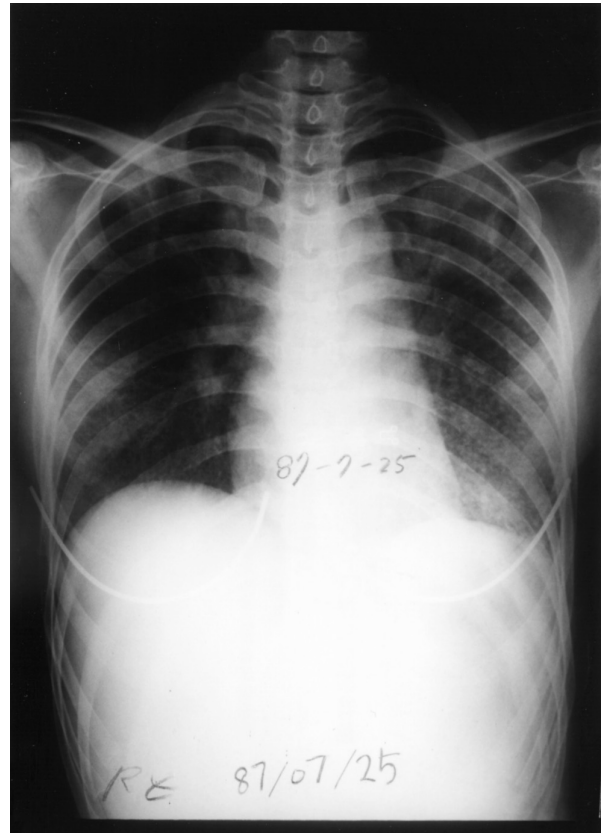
Chest radiograph shows that there were multiple small nodules in both lungs, especially in the lower lung fields, and a mottled opacity in the left upper lung field.
